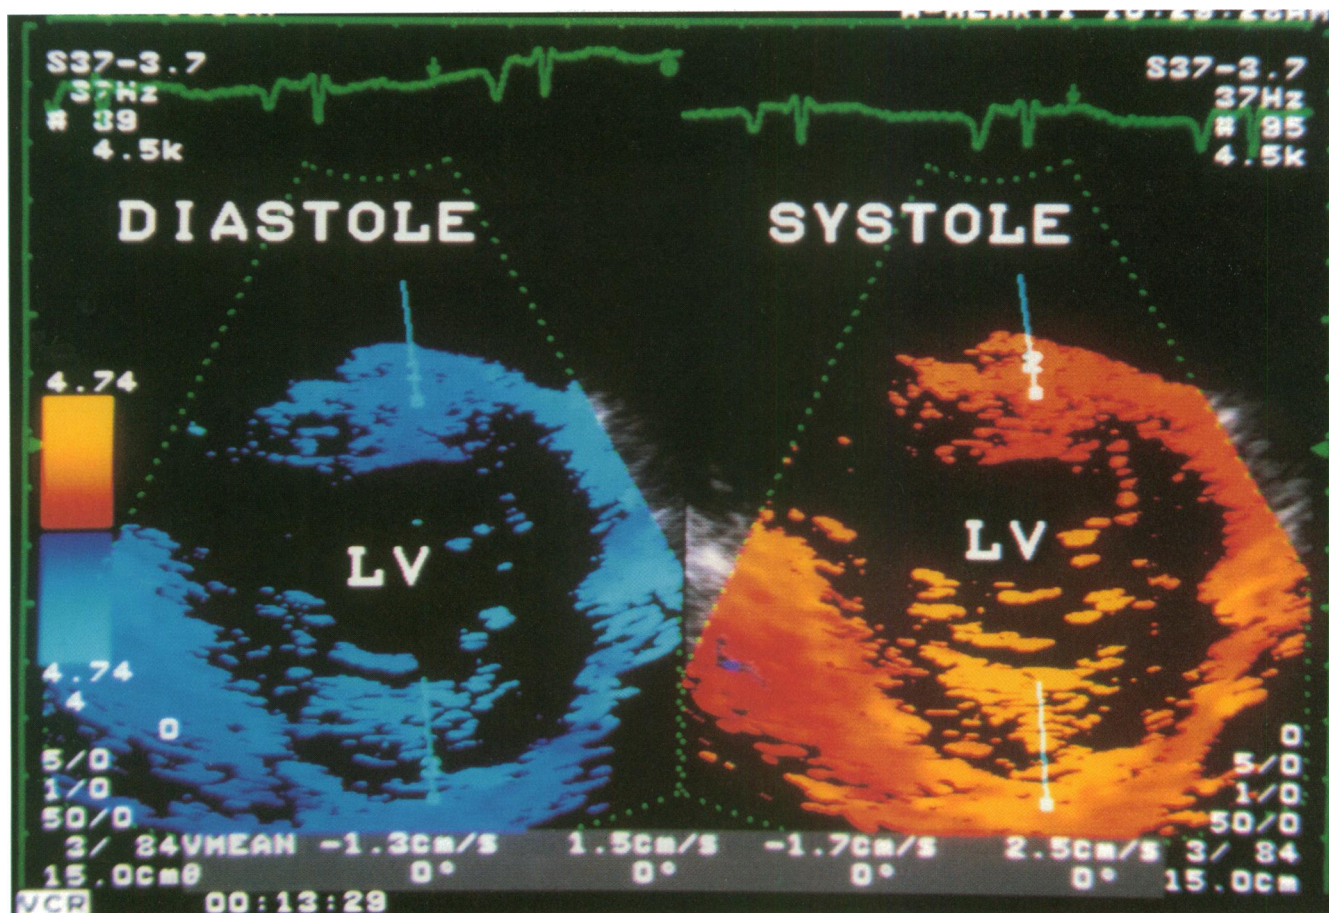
Parasternal short axis tissue Doppler echocardiogram from a subject with cardiac amyloidosis, showing the characteristic sandwich pattern. In both diastole (left) and systole (right) the epicardial and endocardial layers are colour coded, but the velocity of the myocardium is very low and therefore is colour coded black.
